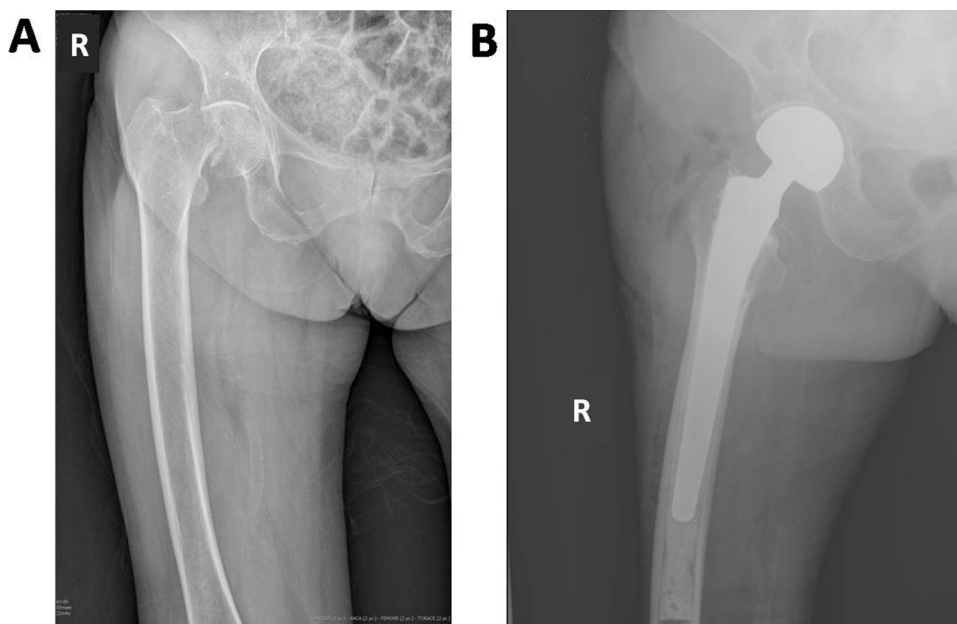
Plain X-ray of the right hip (antero-posterior view) showing femoral neck fracture before (A) and after (B) the surgical procedure.
